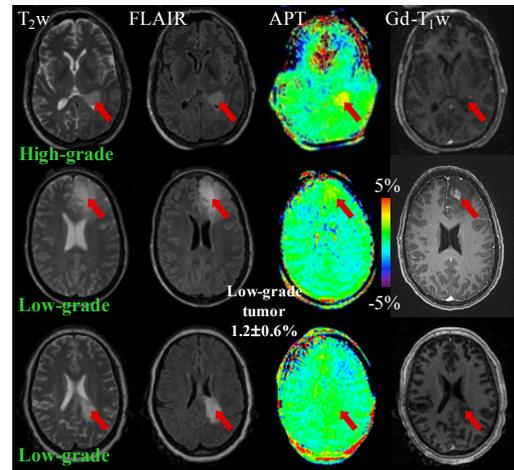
(top row) A brain lesion that showed no Gd enhancement, but was found to be a high-grade glioma at the time of pathology. Such lack of Gd enhancement has been shown to occur in 10% of GBM and 30% of anaplastic astrocytomas. However, APT hyperintensity is clearly visible in the lesion. (middle row) A brain lesion that showed Gd enhancement, but was found to be a low-grade glioma at the time of pathology. It is important that APT shows iso-intensity to minimal hyperintensity within the lesion. (bottom row) Typical APT and conventional MRI characteristics for a patient with a low-grade glioma (no Gd enhancement, APT iso-intensity).
